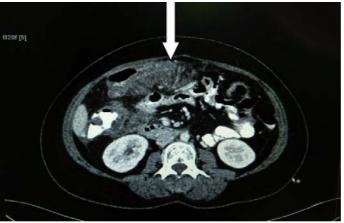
Case of mesenteric panniculitis showing increased CT density of mesentery forming an ill-defined mass (arrow).
